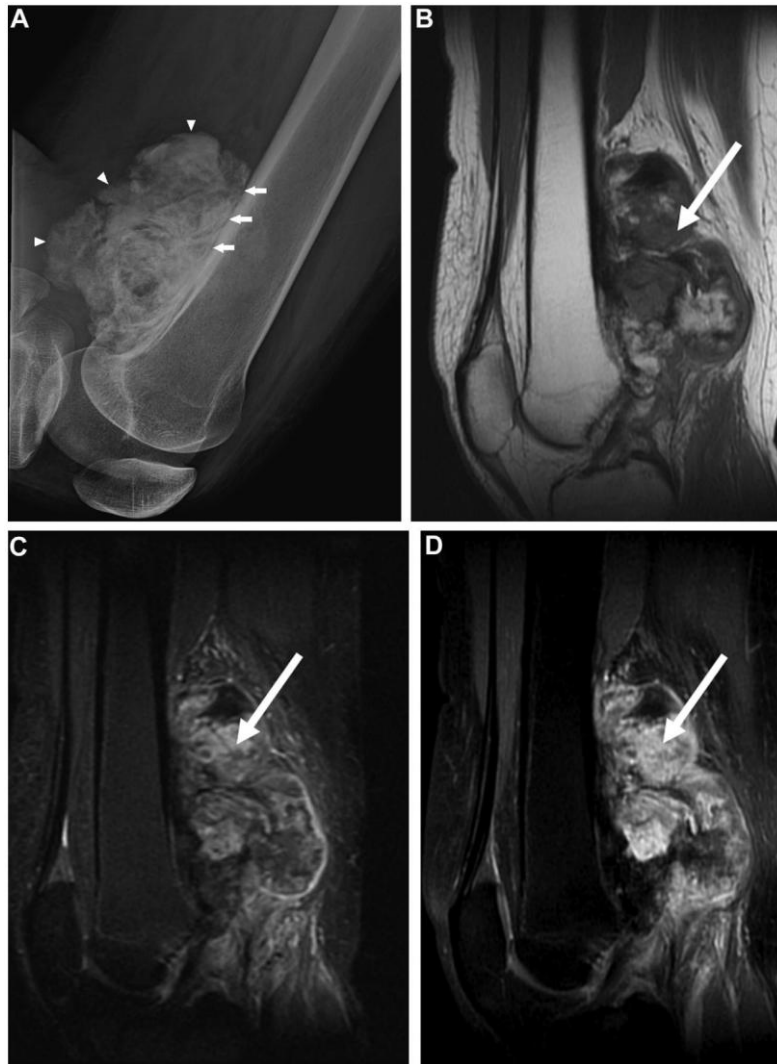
The lateral view of the radiography revealed an ossified mass on the periosteum (arrowheads) with a presence of string sign, a radiolucent line separating the ossified mass and underlying cortex (arrows); MRI of the sagittal section of the mass revealed a heterogeneous signal, with the solid component predominately hypointense on T1-WI (arrow) (1B), hyperintense on T2-WI (arrow) (1C), and well enhancement on T1-WI with fat saturation after gadolinium contrast enhancement (arrow) (1D)
